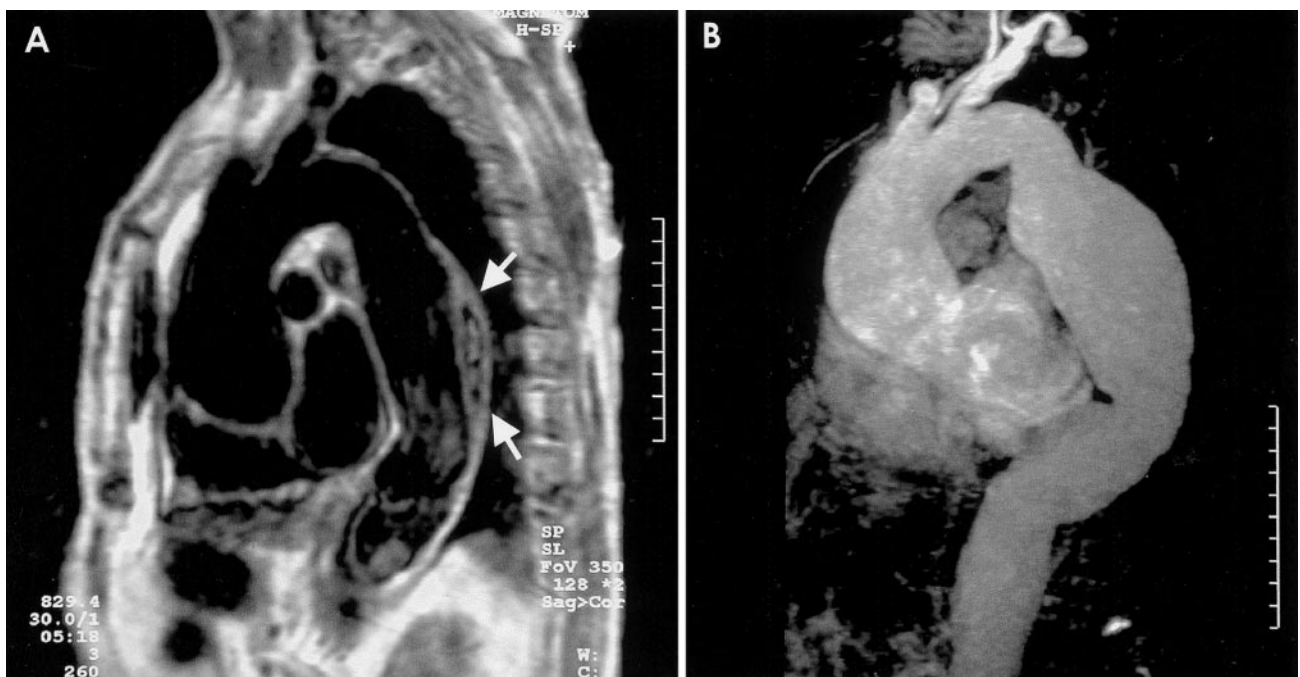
IMH evolution to fusiform aneurysm. A, MRI in sagittal view showing an IMH in the posterior aorta wall (arrows). B, Gradient-echo MRI confirming the evolution to fusiform aneurysm 5 years later.
